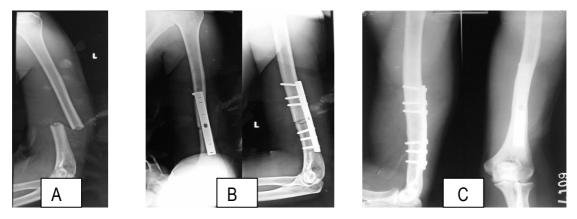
A 25 year old male with fracture shaft humerus treated with plating. A: Pre-operative radiograph; B: Immediate post-operative radiograph; C: Radiograph on 1 year
